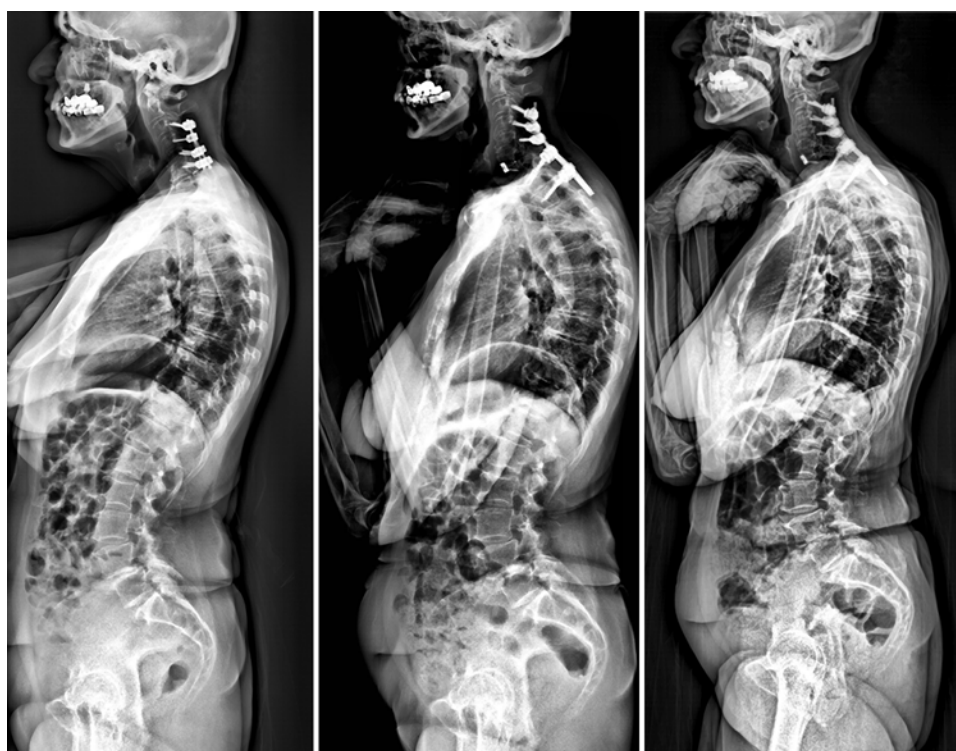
Radiographs of a patient surgically treated with a posterior fusion between C3 and T2. Cervical lordosis improved from -3° (kyphosis) preoperatively (*left*) to $+29^\circ$ (lordosis; *right*). In the meantime, PI-LL increased by 8° , TK by 11° , and TPA by 3° . Regional and global alignment was maintained between 3 months (*center*) and 1-year (*right*).
